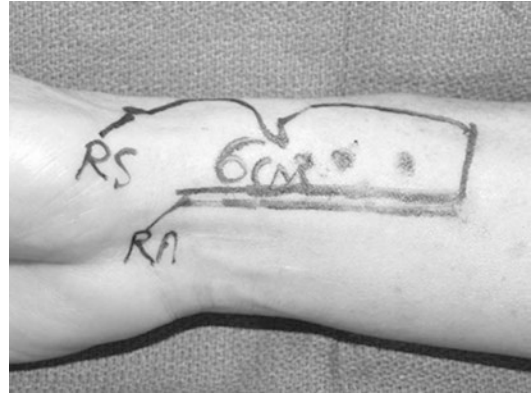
Outline of radial artery and the perforators as identified by ultrasound
